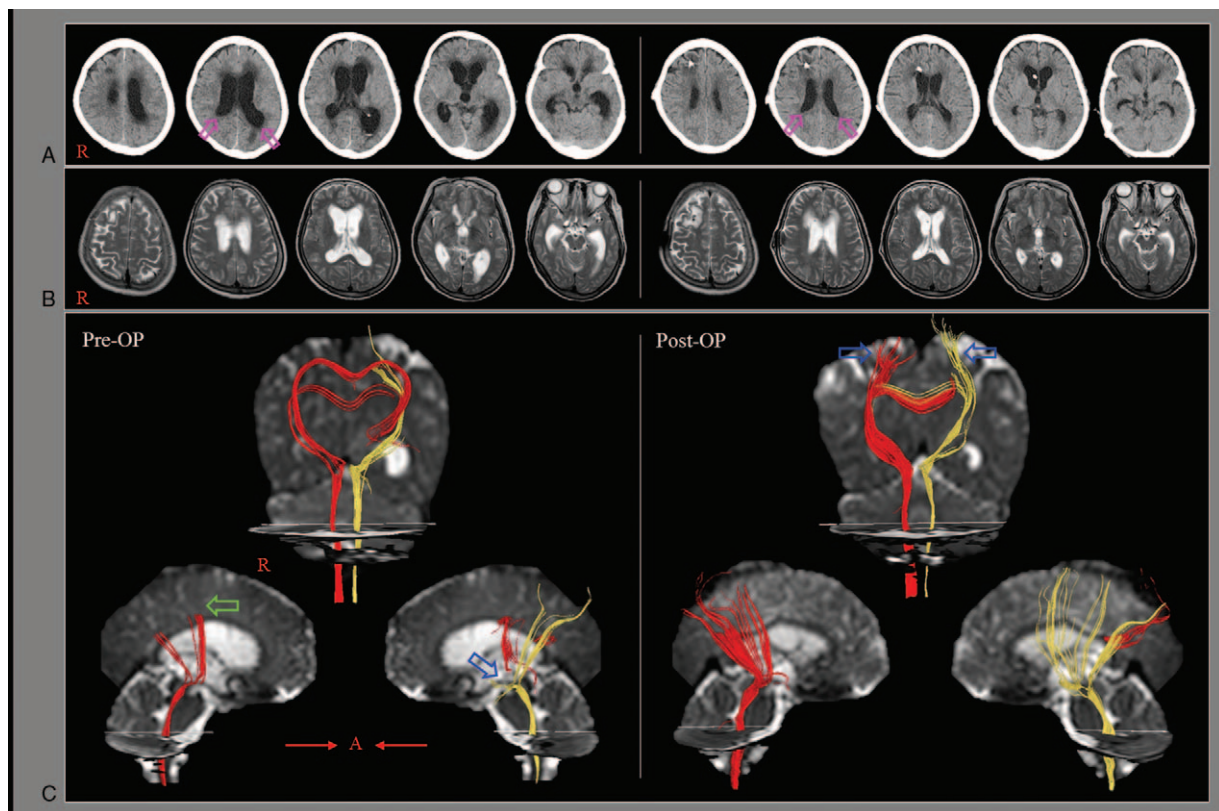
Pre-OP brain CT images (A) and MR images (B) show dilatation of the ventricular system and reduced dilatation of the ventricular system after shunt operation (pink arrows) Results of diffusion tensor tractography (DTT) for the corticoreticular pathway (CRP) (C). On the pre-OP DTT, discontinuations (the right CRP: at subcortical white matter level-green arrow, and the left CRP: at the midbrain level-blue arrow) of the CRP fibers from the premotor cortex were observed in both hemispheres. On the post-OP DTT, the CRP fibers were elongated to the respective premotor cortex in both hemispheres (arrows).
